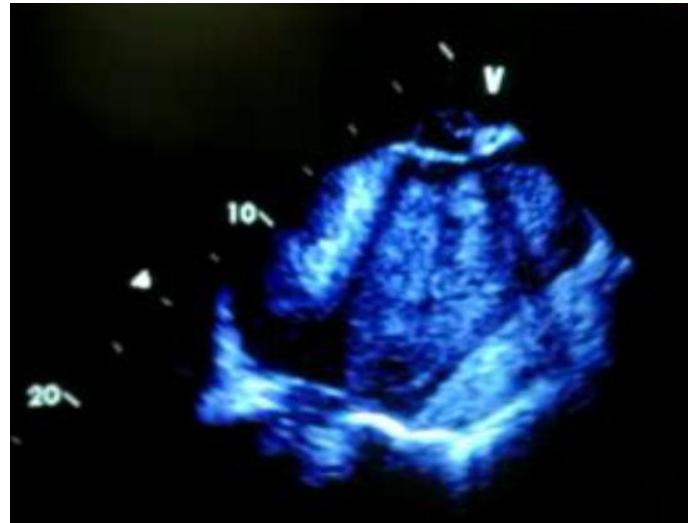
Transthoracic echocardiography showing a giant left atrium.
